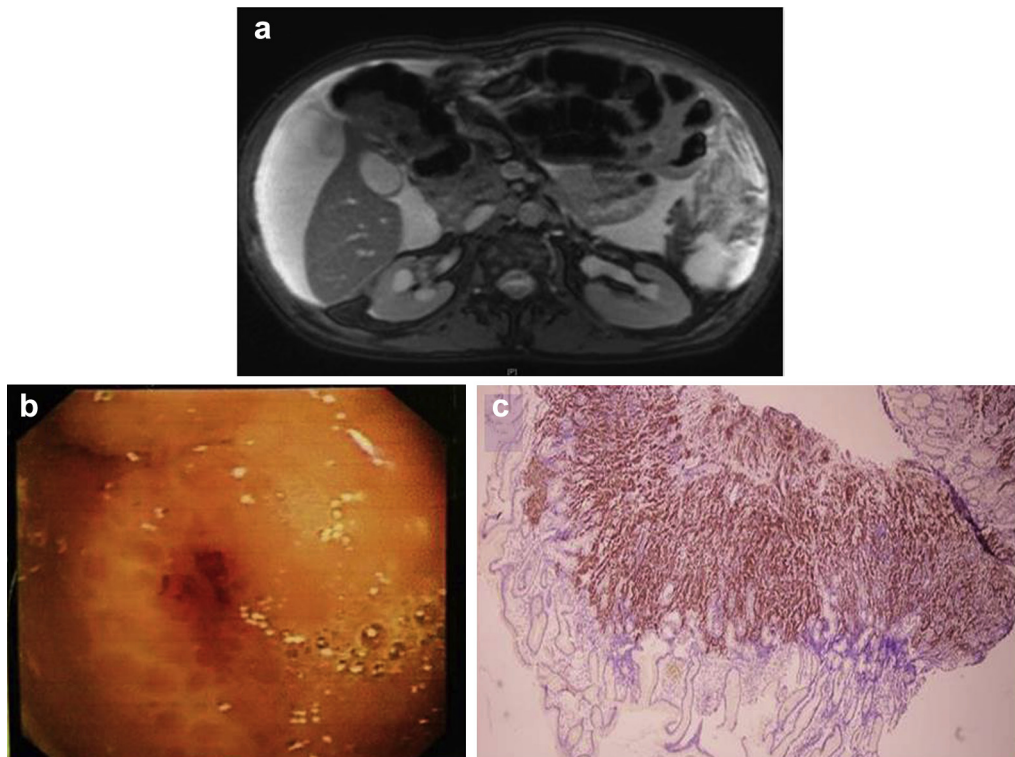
a. MR imaging revealing bilateral hydronephrosis of kidney. b. Endoscopic scene of suspicious area in gastric fundus. c. Diffuse AMACR positivity is seen in nearly all neoplastic cells that obtained from gastric biopsy (immunoperoxidase, $\times 40$).
